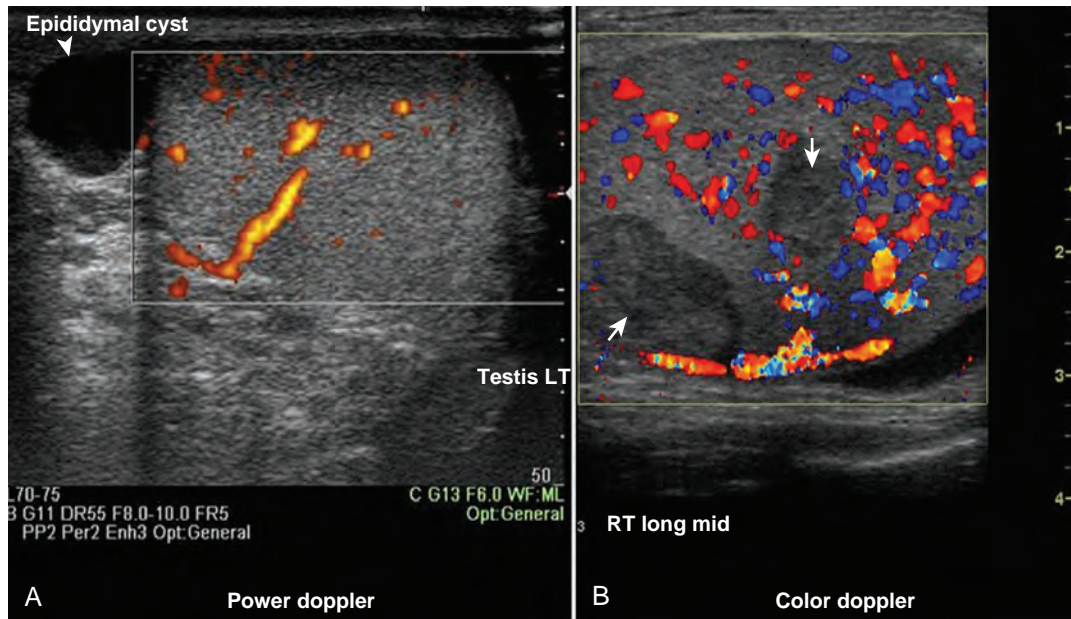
A, Normal intratesticular blood flow by power Doppler; note the epididymal cyst (arrowhead). B, Increased blood flow in an irregular pattern demonstrated by color Doppler was associated with necrotizing vasculitis; note the relatively hypoechoic areas of decreased vascularity (arrows).
